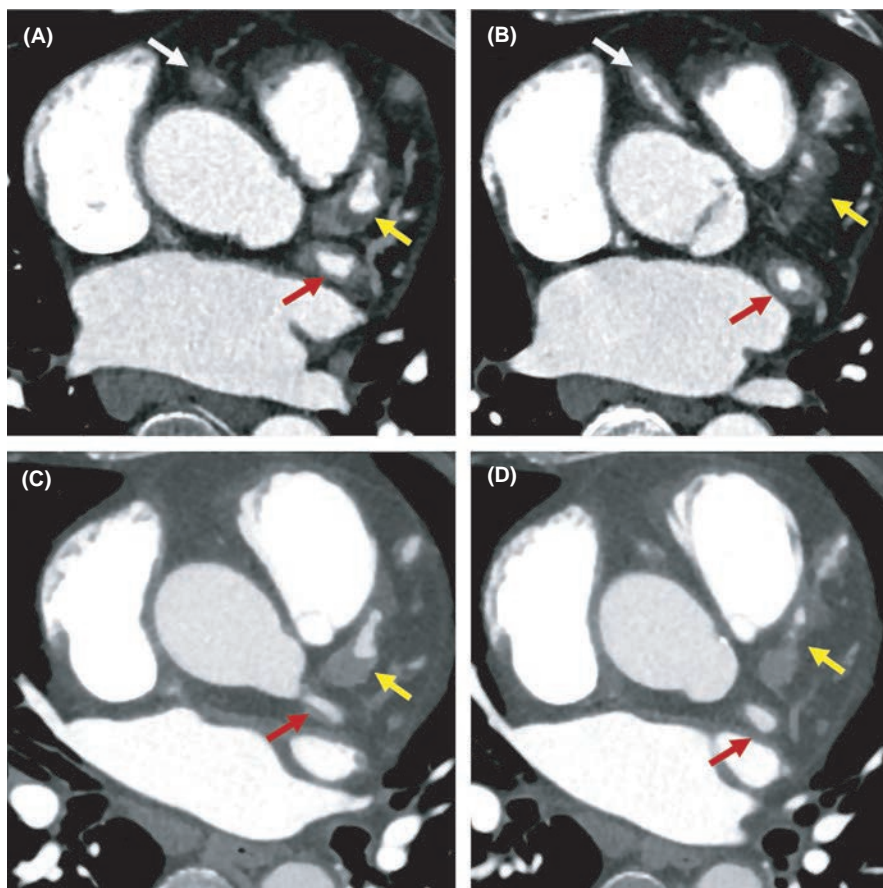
Axial coronary computed tomography angiography (CTA) images show fusiform aneurysms in the left anterior descending artery (LAD) (A-B, yellow arrow) and circumflex (Cx) artery (A-B, red arrow) with accompanying vessel wall thickening. There is also wall thickening in the right coronary artery (A-B, white arrow). Follow-up axial coronary CTA images show that the aneurysms and the thickening of the vessel walls in the Cx (C-D, red arrow) and LAD (C-D, yellow arrow) partially regressed
